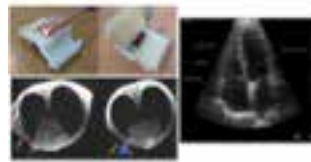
Left: Probe holder with probe; artifact-free images showing probe position on 3D VIBE in vivo. The overlay shows the probe and US imaging plane position. Right: Artifact-free cardiac valve ultrasound image acquired during MRI acquisition.
